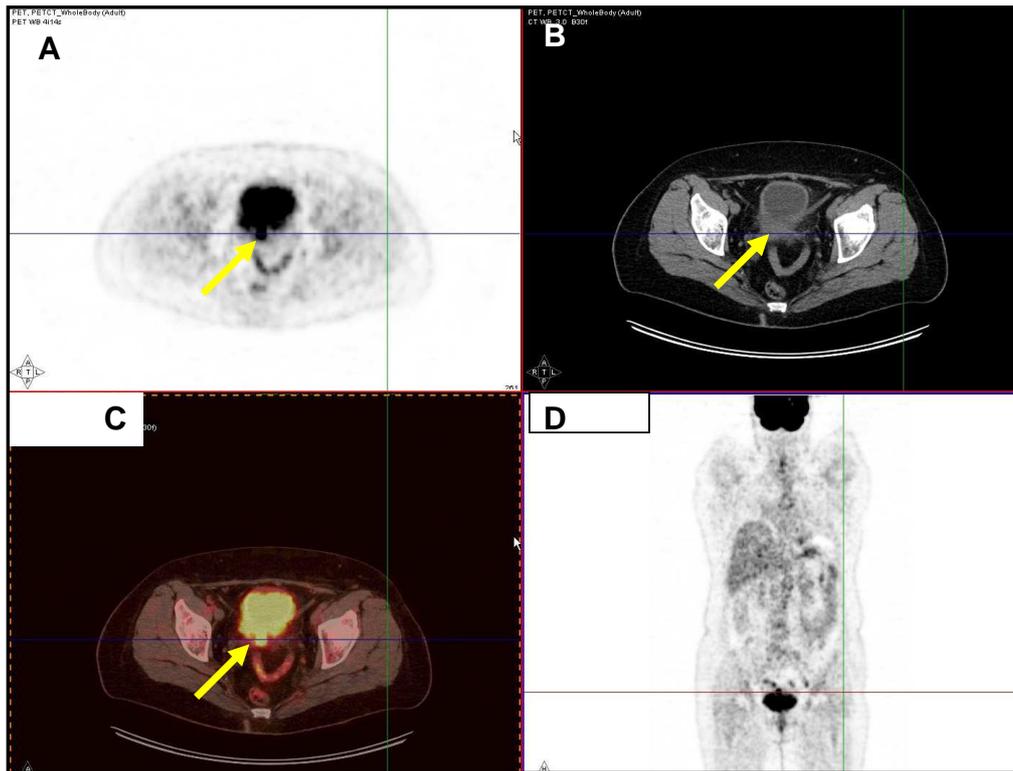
62 years old lady with cancer cervix stage 2B showing retrovesical focal high FDG uptake (A), In the CT image (B), soft tissue recurrence at the primary site (yellow arrow) which is confirmed in the fusion PET/CT (C) and the coronal (D) images.
